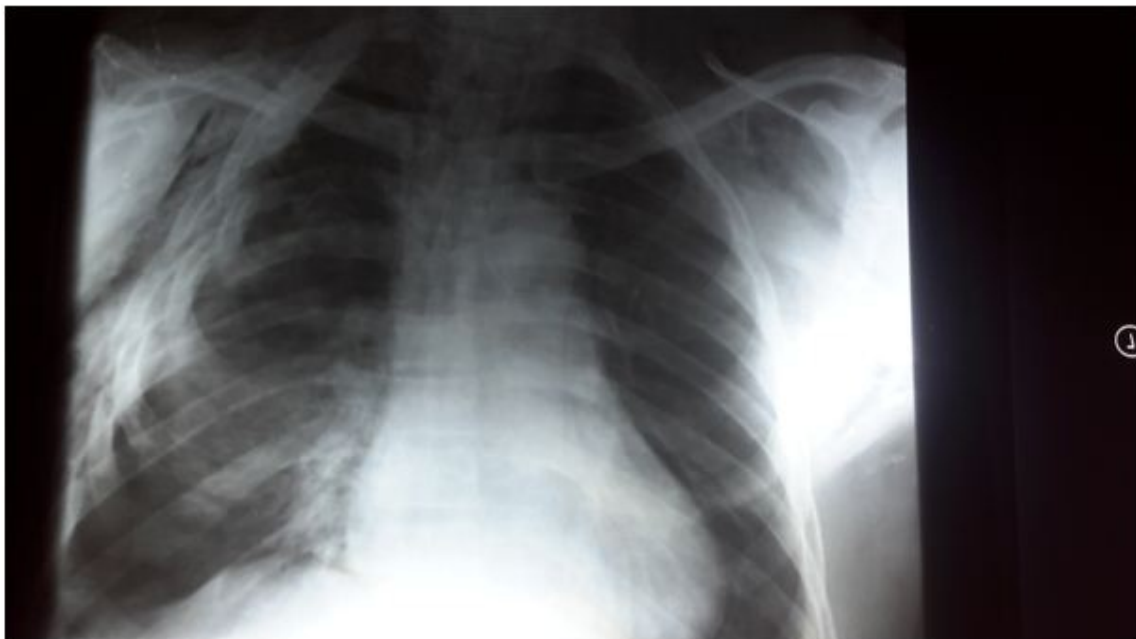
Chest radiograph of the patient showing multiple rib fractures on the right side and subcutaneous emphysema
